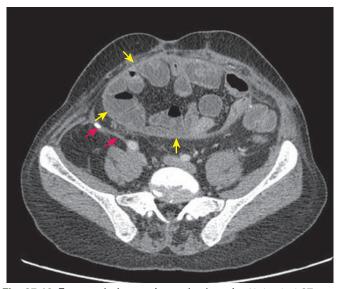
Encapsulating peritoneal sclerosis. Abdominal CT scan from a patient with encapsulating peritoneal sclerosis. *Red arrows* indicate thickened parietal peritoneum with calcification; *green arrows* indicate thickened visceral peritoneum forming a cocoon containing loops of bowel.
